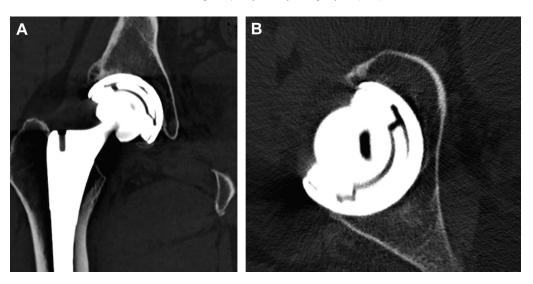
(A) Coronal computed tomography (CT) scan of a fractured ceramic liner. (B) Axial CT scan of a fractured ceramic liner.
